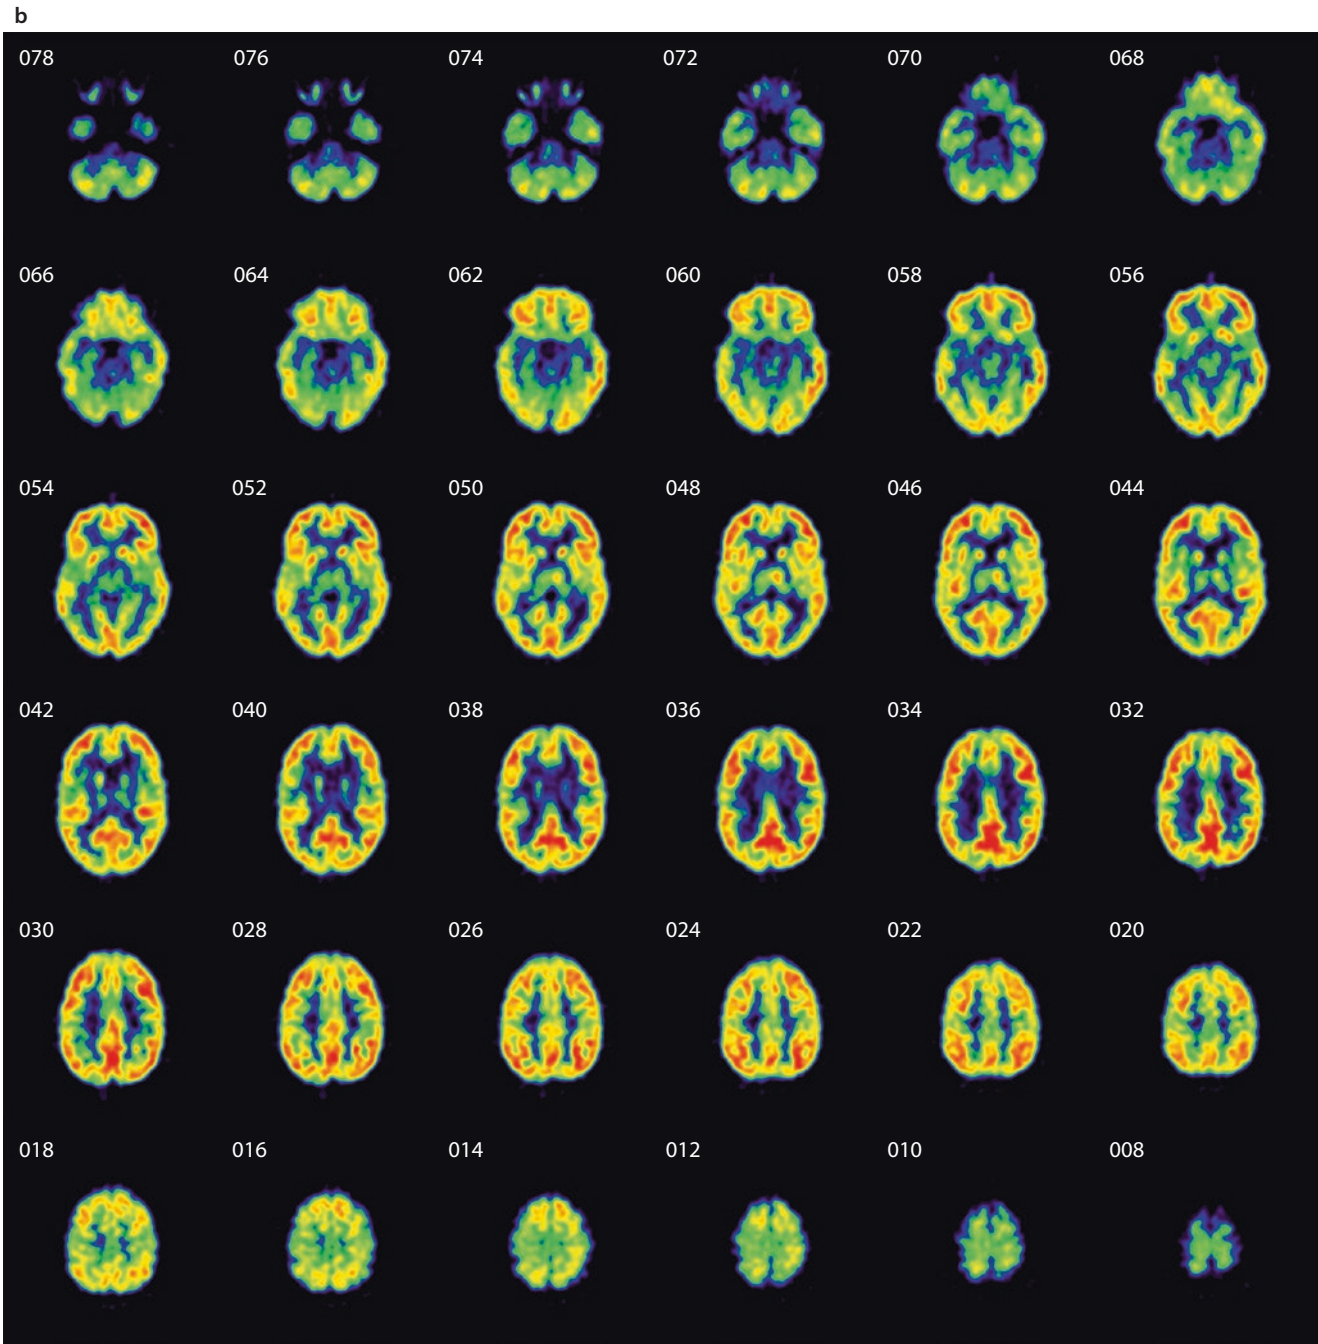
(continued) b High-resolution SPECT rCBF study, showing possible improvements to SPECT imaging; however, such results are only available using brain-dedicated imaging systems, which are mostly found in research environments
